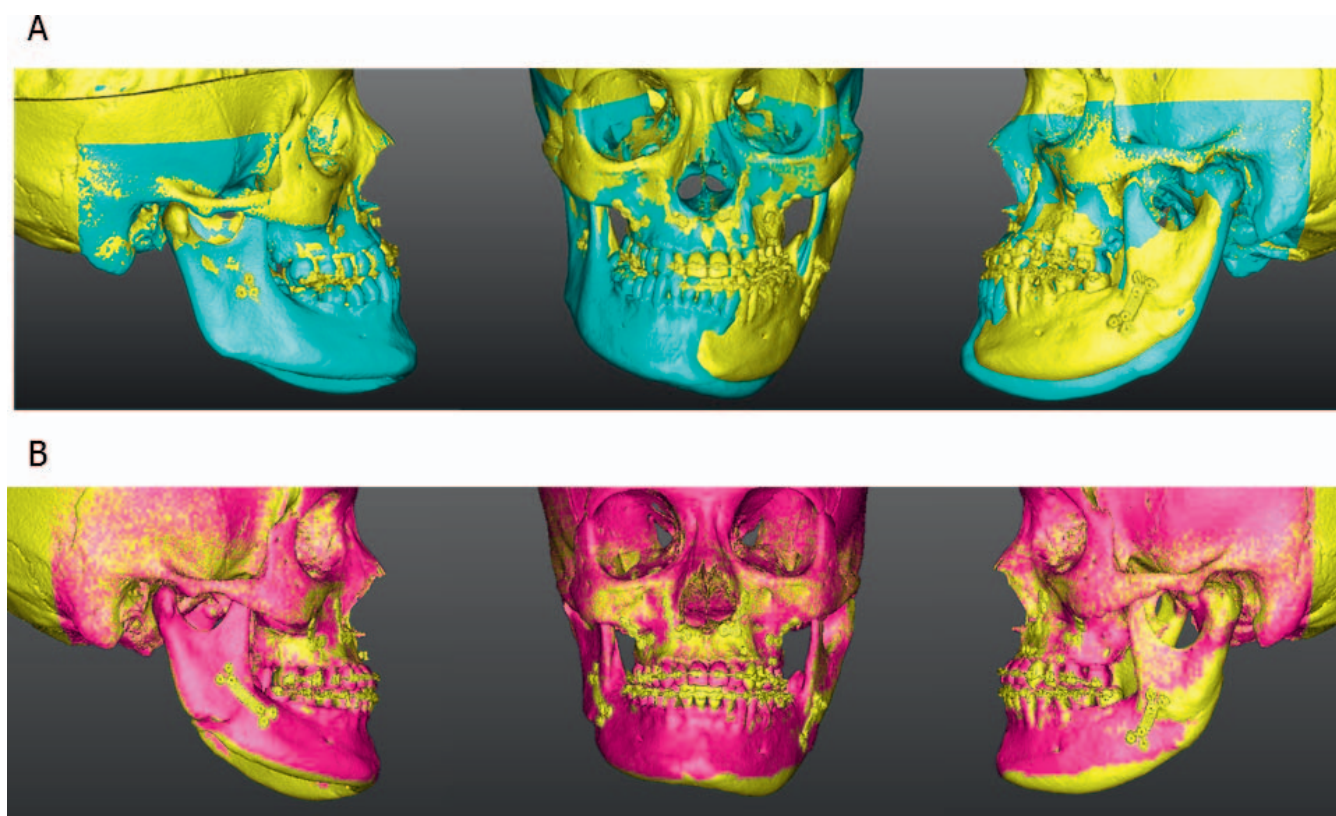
Superimposition of computed tomography images obtained before treatment and after two-jaw surgery (A) and images obtained after two-jaw surgery and during retention at one year (B).
